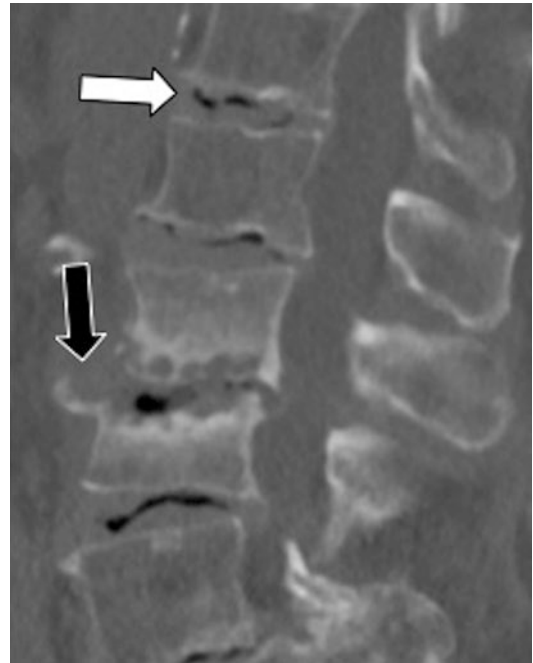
Sagittal CT image of the lumbar spine in a patient with neuropathic/Charcot spine demonstrates multilevel intradiscal vacuum phenomenon (white arrow) and bony debris (black arrow)
